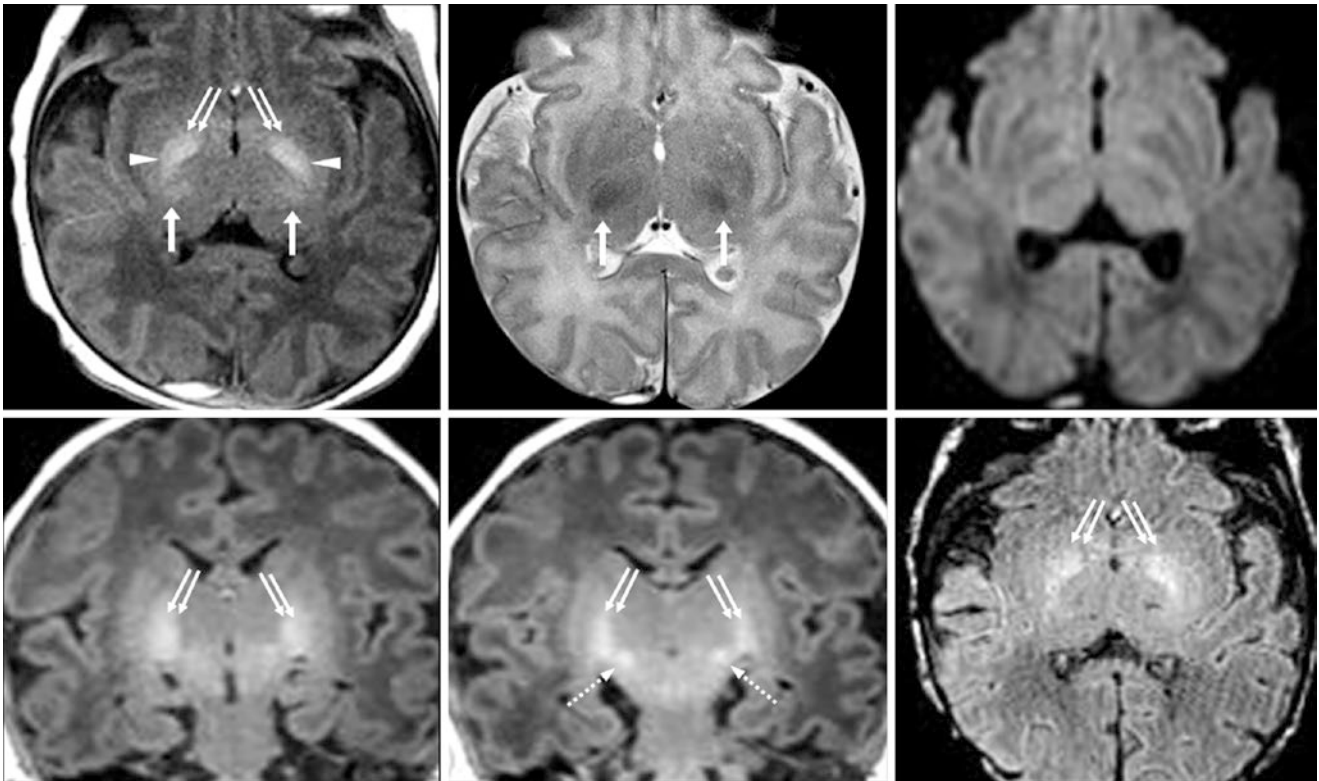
Comparison case of kernicterus. A 15-day-old term neonate with hyperbilirubinemia and hypertonia had a 1.5T MRI that showed profoundly bright signal of the GP (*double arrows*) on GE T1WI (*top left*), with minimal findings on SE T2WI (*top middle*), perhaps representing a milder degree of insult. The lack of findings on
